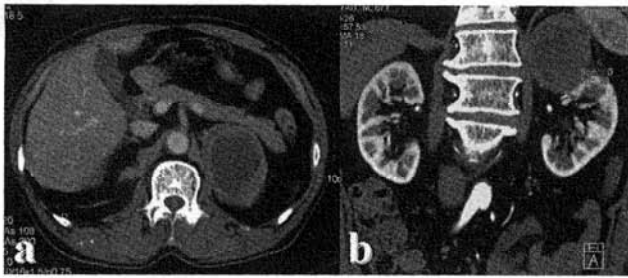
Computed tomography showed a well-defined round, 80×75×60 mm cystic mass with a rim of soft tissue in the left adrenal region. Slight enhancement of the peripheral rim of soft tissue was seen after intravenous administration of contrast material. (a: Axial image, b: coronal image).
